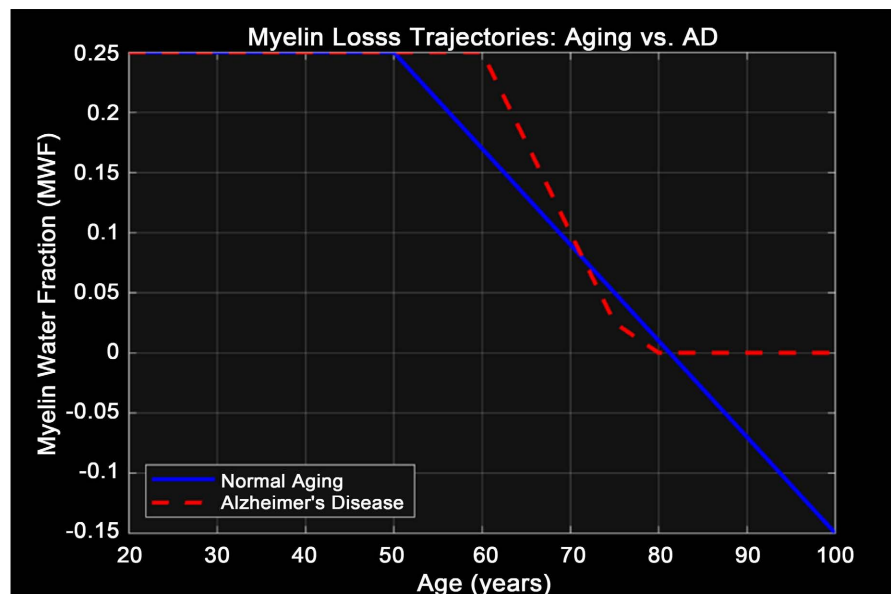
Modeled trajectories of myelin water fraction (MWF) decline in normal aging versus Alzheimer's disease, based on longitudinal human MRI data (Qian *et al.*, 2020 [9]; Kavroulakis *et al.*, 2018 [15]). Real result: By age 80, AD patients show ~25% lower MWF than age-matched controls in temporal/parietal white matter [9].
